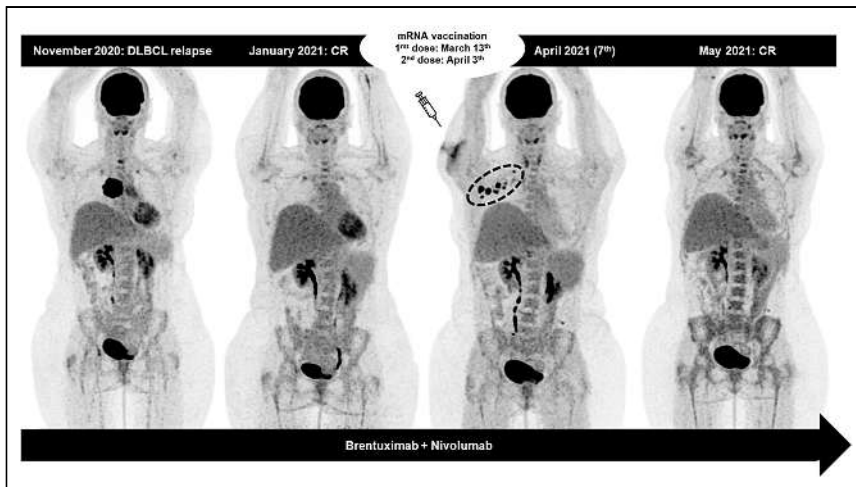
Maximum-intensity-projection ^{18}F -FDG PET images of 45-y-old woman with relapsed DLBCL in mediastinum. Patient was treated with brentuximab and nivolumab and experienced complete metabolic response 2 mo after initiation of therapy (January 2021). Although continuing lymphoma therapy, she received 2 mRNA COVID-19 vaccine injections in right deltoid. ^{18}F -FDG PET/CT scan 4 d after last vaccine dose (April 2021) showed several HLNs (encircled). On subsequent ^{18}F -FDG PET/CT scan 1 mo later, HLNs disappeared, strongly suggesting their relation to vaccination. This clinical presentation thus highlights presence of v-HLNs in patient younger than 50 y and with normal ALC at time of ^{18}F -FDG PET/CT, which was performed less than 30 d after last vaccine dose. CR = complete response; DLBCL = diffuse large B-cell lymphoma.
